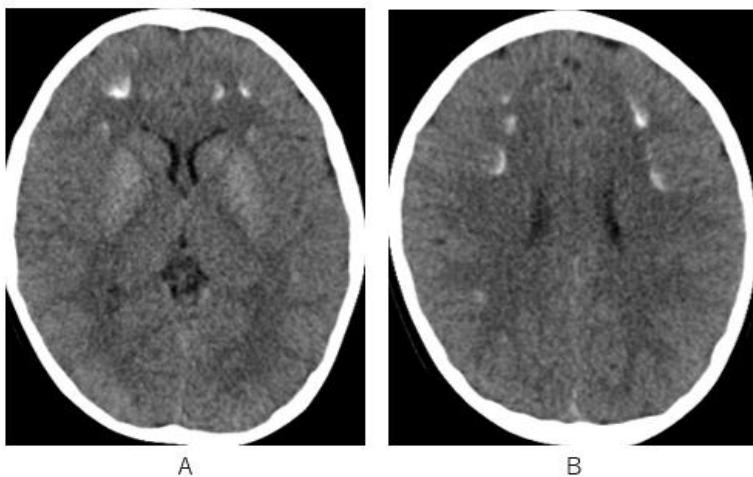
Axial images of brain CT depict high attenuation areas of cortex adjacent to deep white matter in frontal lobe (A, B) and slight high attenuation of caudate nucleus and basal ganglion (A).
